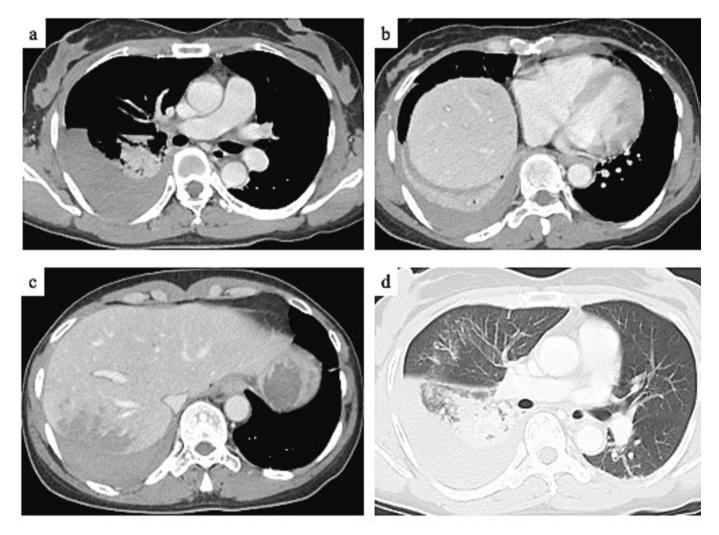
Chest CT shows a moderate hemothorax, a hepatic injury with mild hemoperitoneum, and no pneumothorax.
